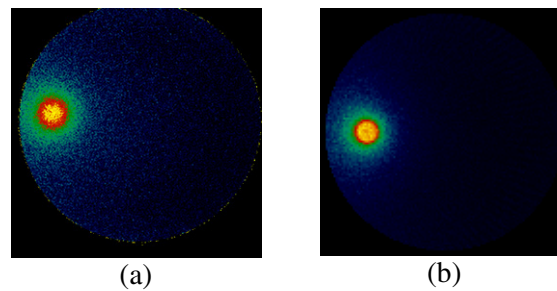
Dose maps obtained from the MR imaging of the Fricke gel (a) and the Monte Carlo calculation (b).
